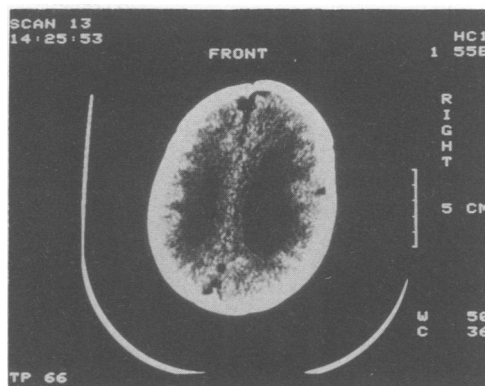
Case 1 aged 3 months and CT scan at 3 months.
